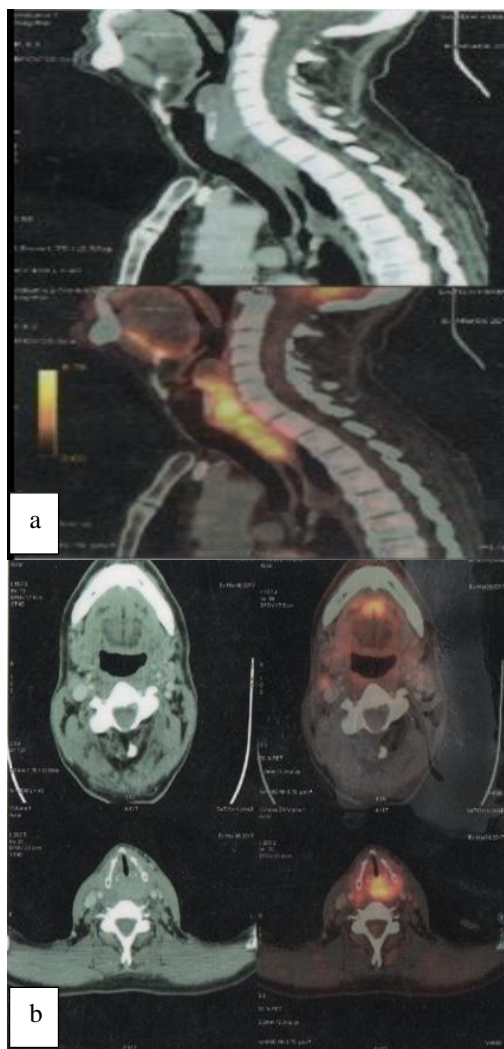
a) Sagittal view on PET-CT shows ill-defined growth by FDG uptake in cervical esophagus extending to thoracic esophagus. b) Cross sectional view shows growth by FDG uptake in buccal mucosa
